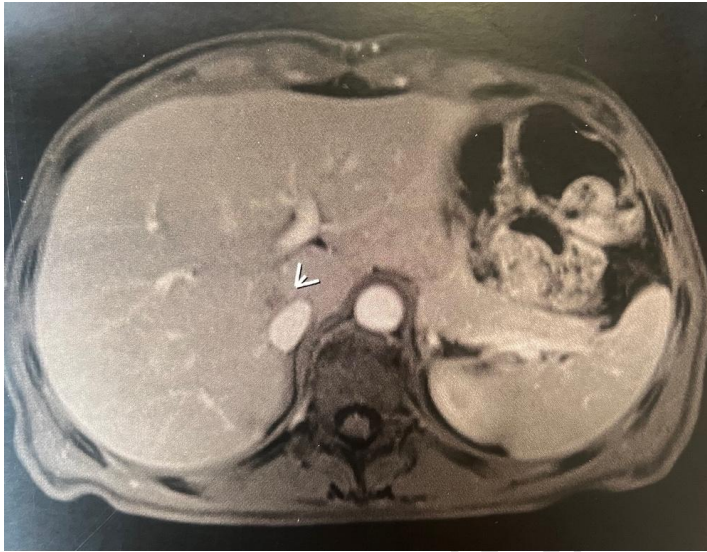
Post-operative MRI of the liver
